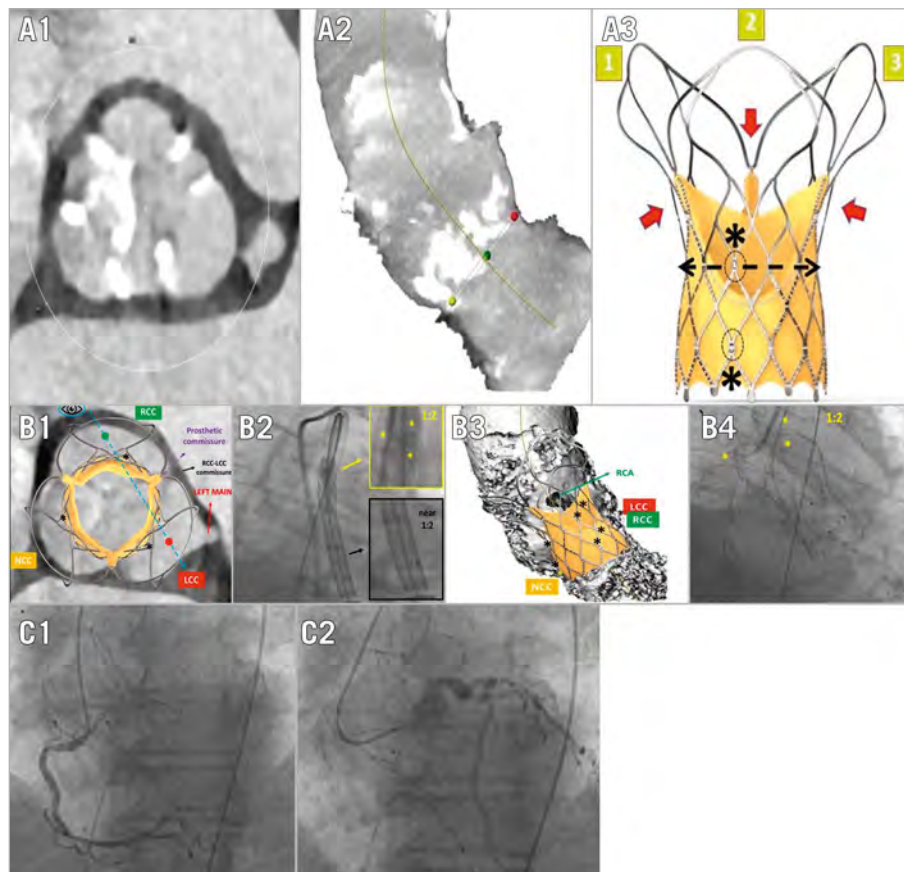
Commissural alignment with Hydra THV. Computed tomography showing severe aortic valve stenosis (A1), with 3-cusp view reconstruction (A2). The novel Hydra THV (A3) with the three-tentacle design (1,2,3) and commissural posts (red arrows) at their bases; six radiopaque markers are located three by three in two rows (black asterisks), each asymmetrically positioned between two prosthetic commissures (dashed lines). Proper commissural alignment (B1) is achieved using the RCC-LCC overlap view (B2, blue dashed line in B1) when one tentacle is on the left and the other two appear on the right (yellow box in B3); the radiopaque markers are seen in a “near 1:2 pattern”, without complete overlap of those located on the right side (black box in B3). Final angiographic result in RCC-LCC overlap view (B4). Easy right (C1) and left (C2) coronary artery reaccess. LCC: left coronary cusp; NCC: non-coronary cusp; RCA: right coronary artery; RCC: right coronary cusp; THV: transcatheter heart valve
